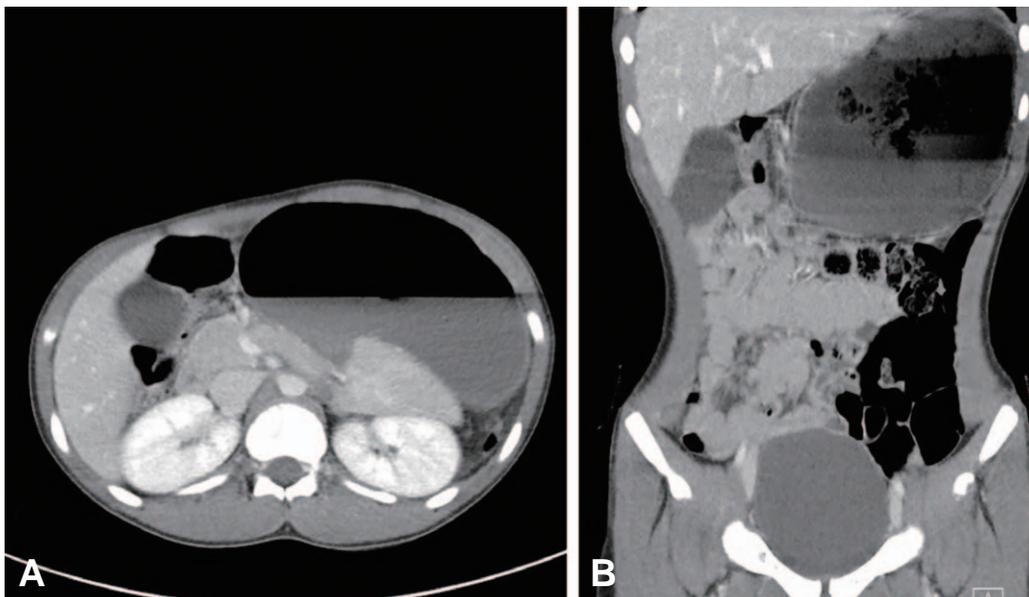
Computed tomography scans (axial, A; coronal, B) showing a gastric distension without signs of ischemia, mass or inflammatory focus.
